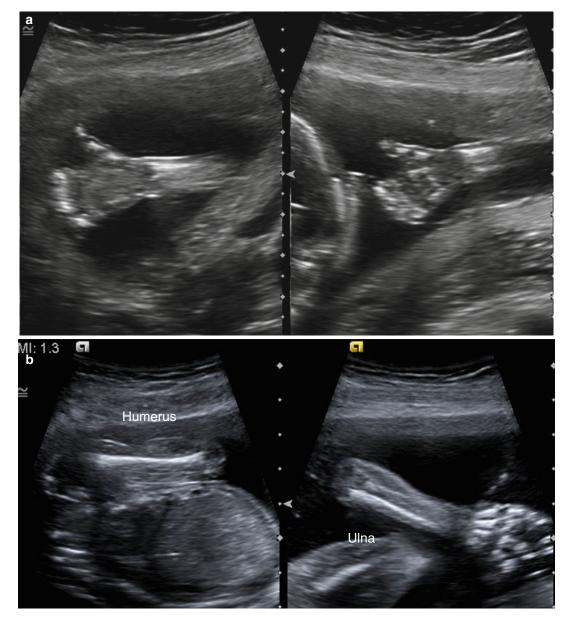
Prenatal sonogram at 20 weeks shows normal appearance of distal forearm bones and hand bones including metacarpals/phalanges (a). Humerus, ulna and proximal radius are also well visualised (b)
